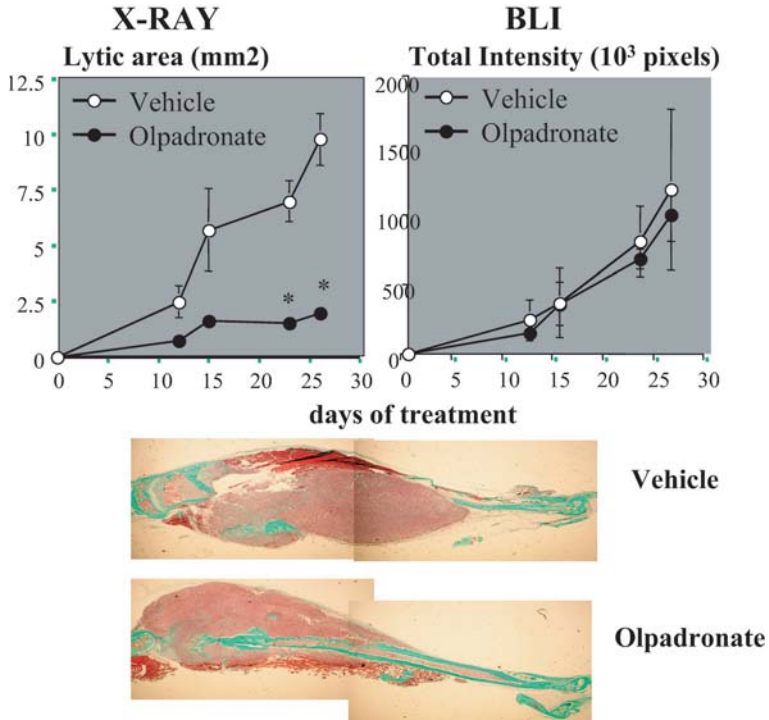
Effect of the potent antiresorptive bisphosphonate Olpadronate on established MDA-B-*luc* tumors growing in bone. For this purpose, 100,000 MDA-B-*luc* cells were intraosseously inoculated and daily treatment with Olpadronate started 14 days after inoculation, when small tumors were established. Osteolysis was measured using X-ray radiography and tumor progression was measured using BLI
